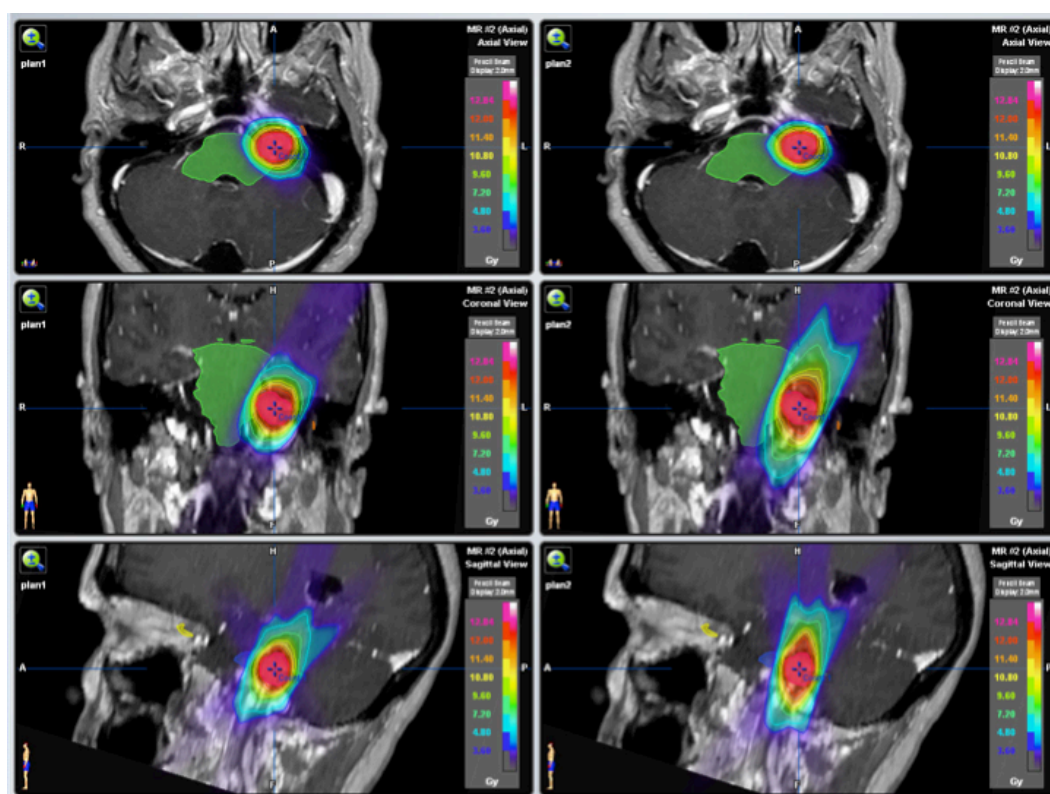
From left to right: magnetic resonance images (MRI) of radiation isodose curves corresponding to two different external beam radiotherapy tentative plans for a same patient. [This image is used under permission of the Hospital Universitario Puerta de Hierro Majadahonda, Madrid, Spain].
